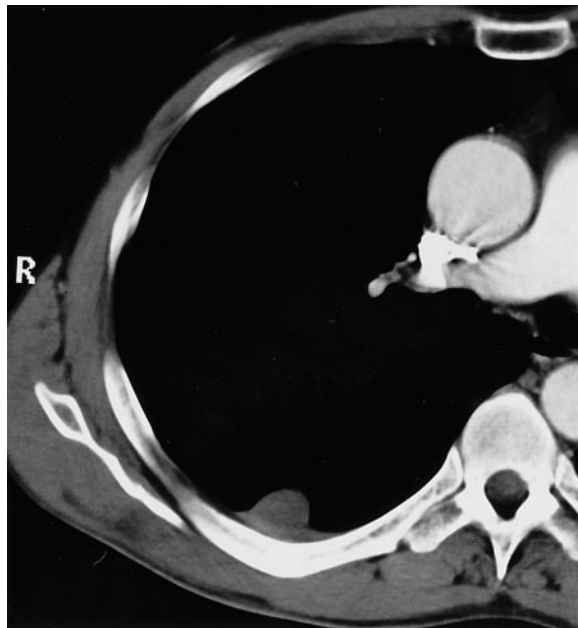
Contrast enhanced CT with the lesion on the right dorsal thoracic wall.
